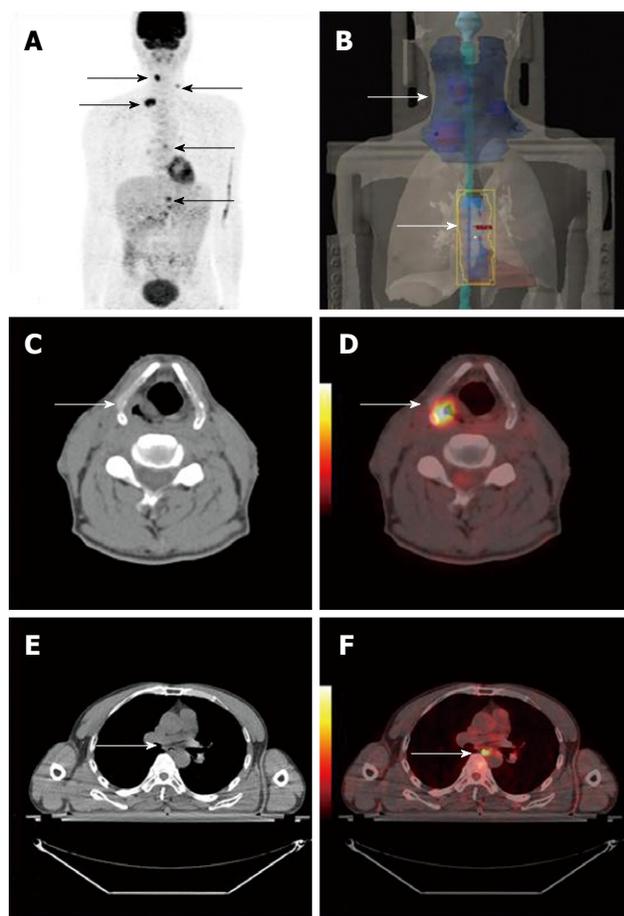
A 53-year-old woman with synchronous hypopharynx cancer combined with esophageal cancer. Positron emission tomography/computed tomography (PET/CT) images revealed hypermetabolic hypopharynx and esophageal lesions, and multiple hypermetabolic supraclavicular, mediastinal lymph nodes (arrows in A). PET/CT imaging guided radiation plan (arrows in B). CT and PET/CT fused images showed hypermetabolic hypopharynx and esophageal lesions (arrows in C, D, E, F).
